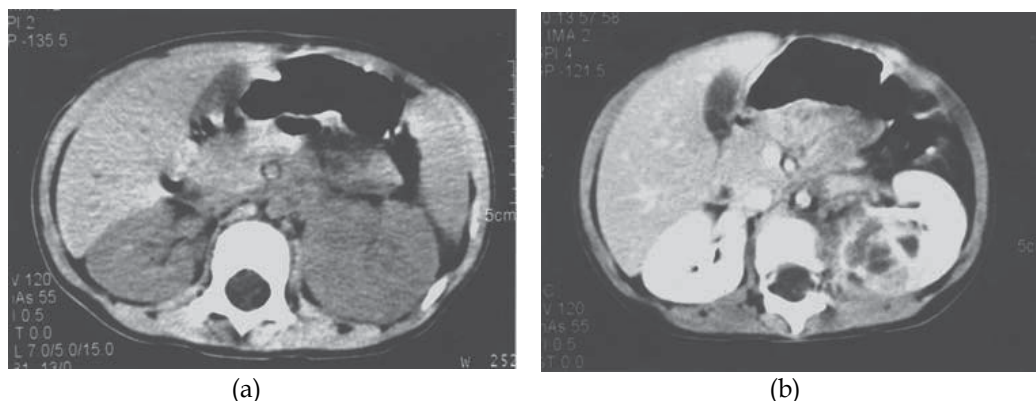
The characteristic non-enhanced (a) and contrast-enhanced (b) CT scans for a 2-year-old patient with acute lobar nephronia, who presented with severe left nephromegaly while without a focal mass sonographically. Note no attenuation area seen in the kidney before enhancement (Cheng *et al.*, 2004).
